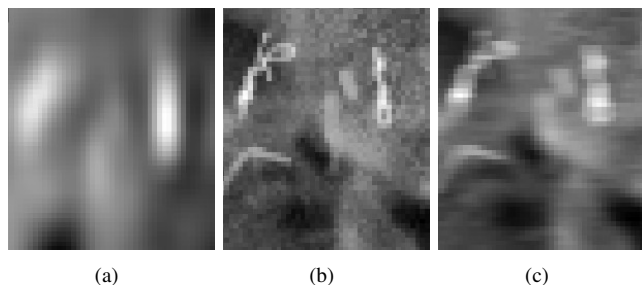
(a) Fiducial appearance in a DRR. (b) Fiducial appearance in a cone-beam projection before convolution. (c) Fiducial appearance in a cone-beam projection after convolution with a blurring kernel.
